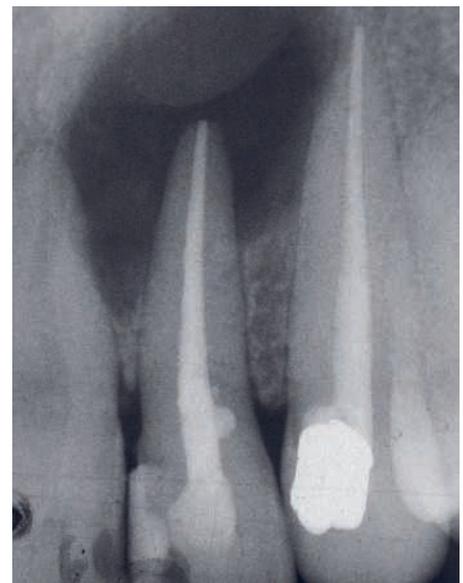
Periapical Radiolucency (Radiograph courtesy of Dr. P. L. Tomson)
